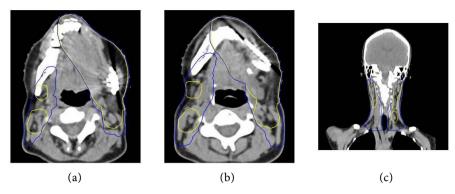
Axial (a) (b) and frontal (c) views of the planning CT scan showing the target volumes: PTV-HR and PTV-LR in yellow and blue, respectively.
